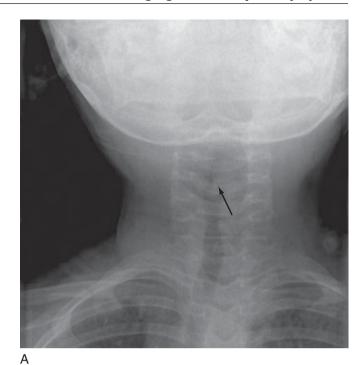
Epiglottitis: 2-year-old girl with respiratory distress and stridor. Anteroposterior radiograph (A) demonstrates an indentation on the left side of the subglottic airway (*black arrow*) with resultant asymmetrical narrowing of the subglottic airway. On the lateral radiograph (B), there is thickening of the aryepiglottic folds (*curved white arrow*) and epiglottis (*white arrow*), resulting in a thumb-like configuration.
